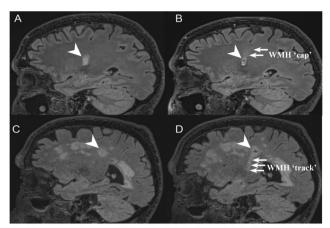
Two representative cases of WMH 'cap/track'. A, Baseline MRI 3 d after stroke onset showed a symptomatic lacunar infarct in the left internal capsule (white arrowhead). B, Follow-up MRI 425 d after onset, superior to the index infarct, showed an ascending WMH cap (white arrows). C, Baseline MRI 36 d after stroke onset showed a symptomatic lacunar infarct in the right centrum semiovale (white arrowhead). D, Follow-up MRI 476 d after onset, inferior to the index infarct, showed a descending WMH 'taxk' (white arrows).
